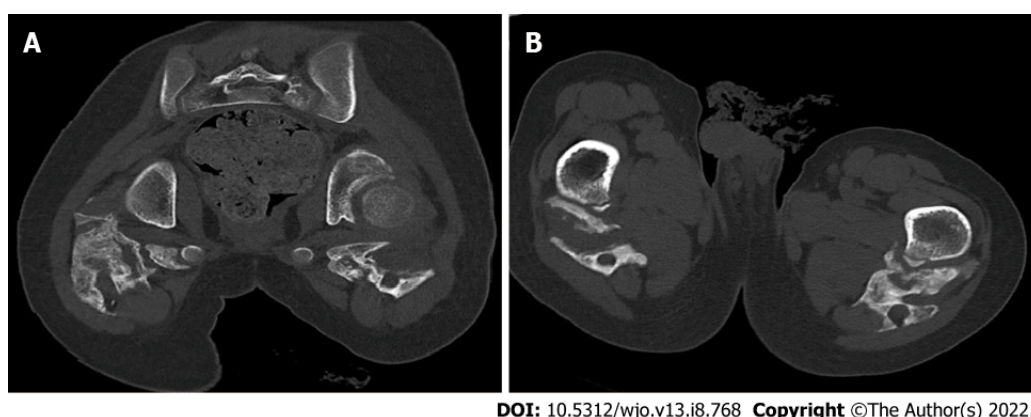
Computed tomography and axial view. A: A proximal section showing ossification of the gluteal and posterior thigh musculature; B: A distal section showing ossification around the sciatic nerve.
